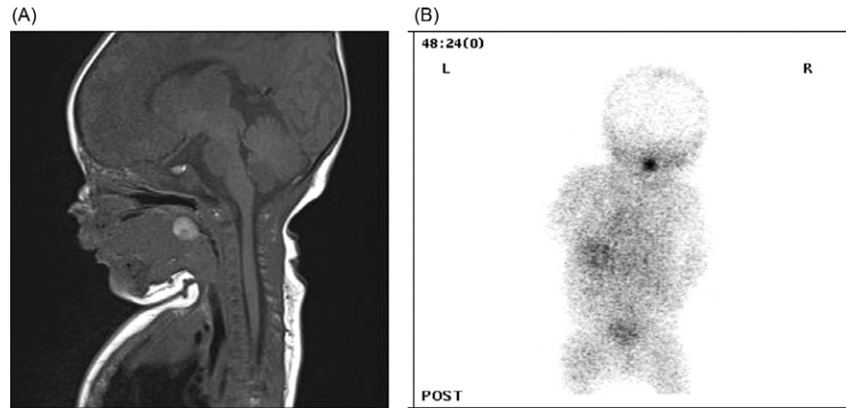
(A) MRI demonstrating an ectopic thyroid gland in a baby investigated for stridor. (B) Technetium radioisotope scan demonstrating thyroid ectopia.
